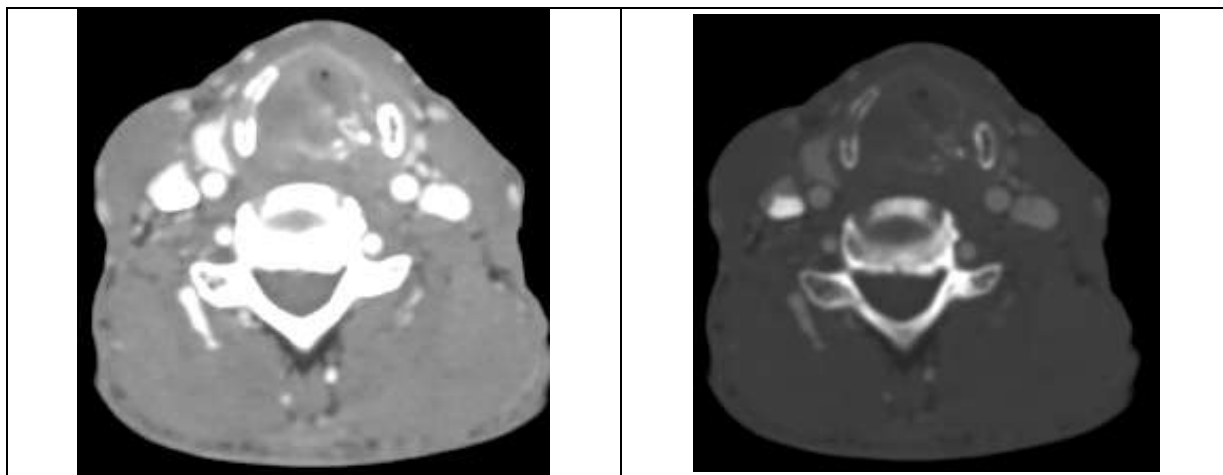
(a) and 12(b): Axial CECT and CT bone images at the level of arytenoid cartilage in a case of Ca transglottis shows sclerosis and invasion of arytenoid cartilages
